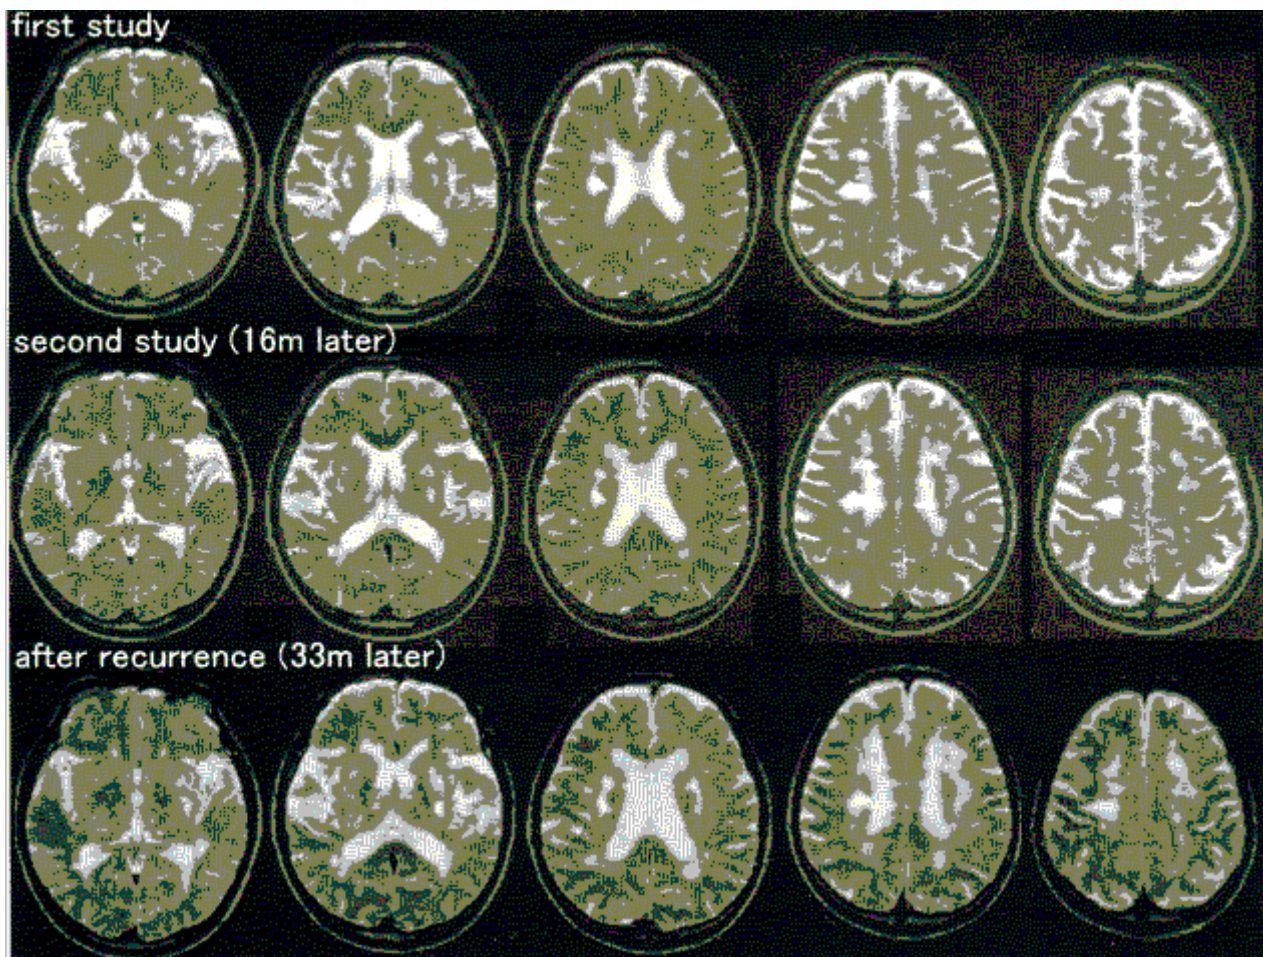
An example of progression of white matter high-intensity lesions (WML) before the occurrence of a stroke in a 68-year-old man with lacunar infarcts.¹⁷ The first magnetic resonance imaging (MRI) study (top row) shows multiple lacunar infarcts in the bilateral basal ganglia and WML (score = 8). The second study 16 months later (middle row) shows an asymptomatic increase in the number and extent of WML (score = 11) in the bilateral hemispheres. At this time, the control of diabetes mellitus was poor and cholesterol level was increased. A subsequent lacunar infarction occurred 17 months after the second study, with a further increase in the extent of WML (score = 14) (bottom row).
